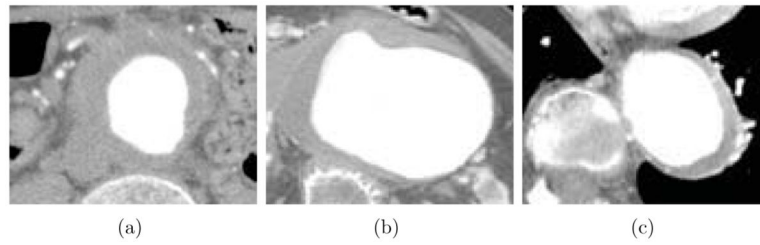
CTA image variability makes thrombus segmentation challenging. (a) Poorly visible thrombotic surface. (b) Irregular thrombus geometry. (c) Strong image intensity gradients near the spine, the heart and the lungs.
